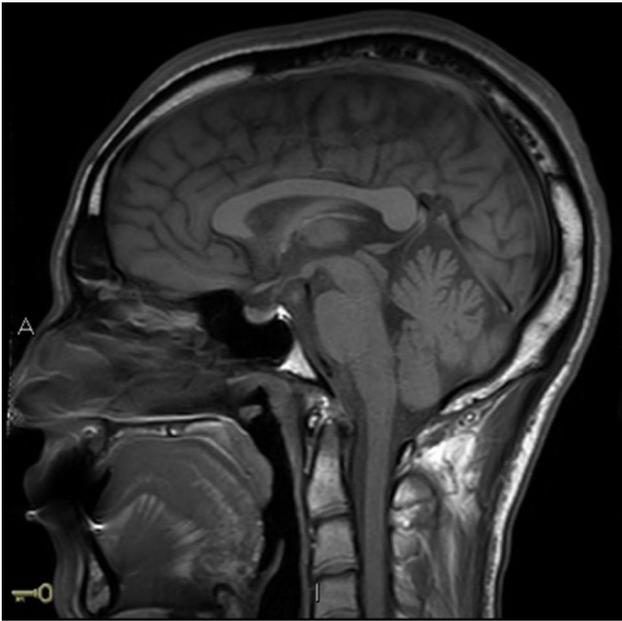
Multiplanar MRI without contrast showing polypoid lesion at junction of the posterior nasal cavity and nasopharynx
